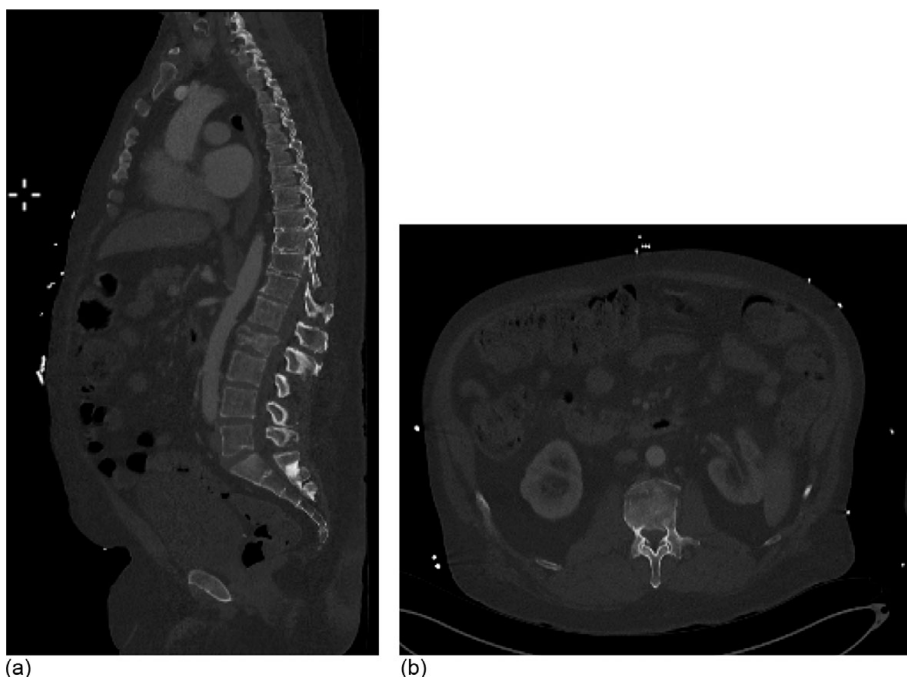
(a) Sagittal CT reconstruction thoracolumbar spine and (b) axial cut at area of interest
